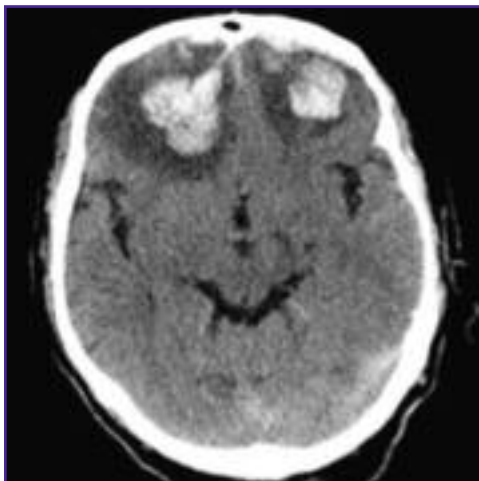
CT scan of head showing the evolution of both frontal lobe hyperdensities, with parafalcine subdural hematoma and minor subarachnoid hemorrhage.
